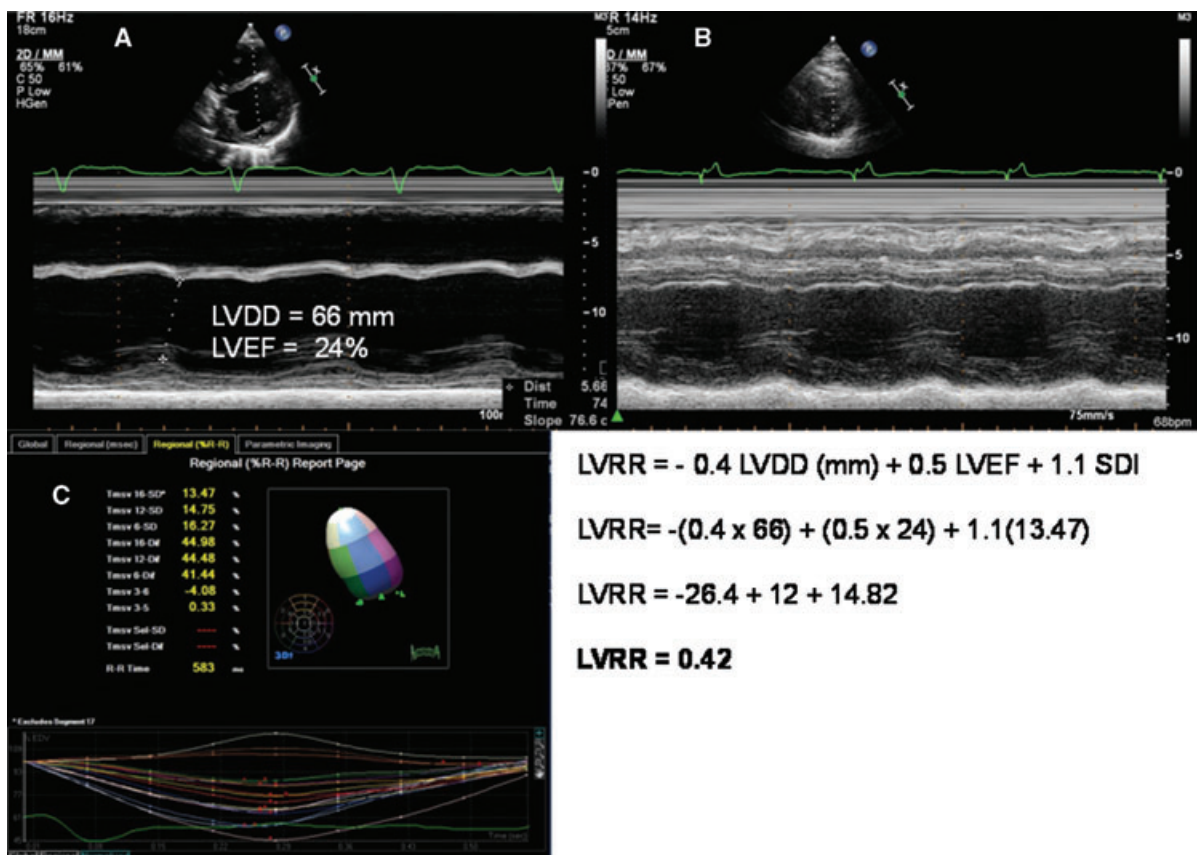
M-mode echocardiogram from a responder patient pre-CRT A. and post-CRT B. SDI before CRT was estimated in 13.47% C. After CRT, the patient presented with reductions of left ventricular volumes and increases in left ventricular ejection fraction (LVEF). LVDD = left ventricular end diastolic diameter.
